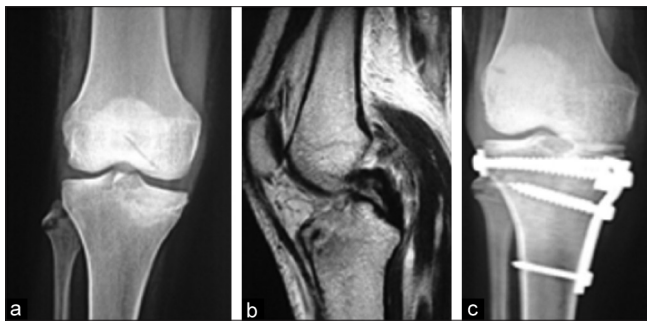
(a) Plain radiographs of right knee anteroposterior (AP) view, showing undisplaced lateral collateral ligament avulsion, type 4 schatzker tibia condyle fracture (b) MRI of right knee showing posterior cruciate ligament rupture (c) Postoperative plain radiographs of right knee (anteroposterior view), with buttress plating done
